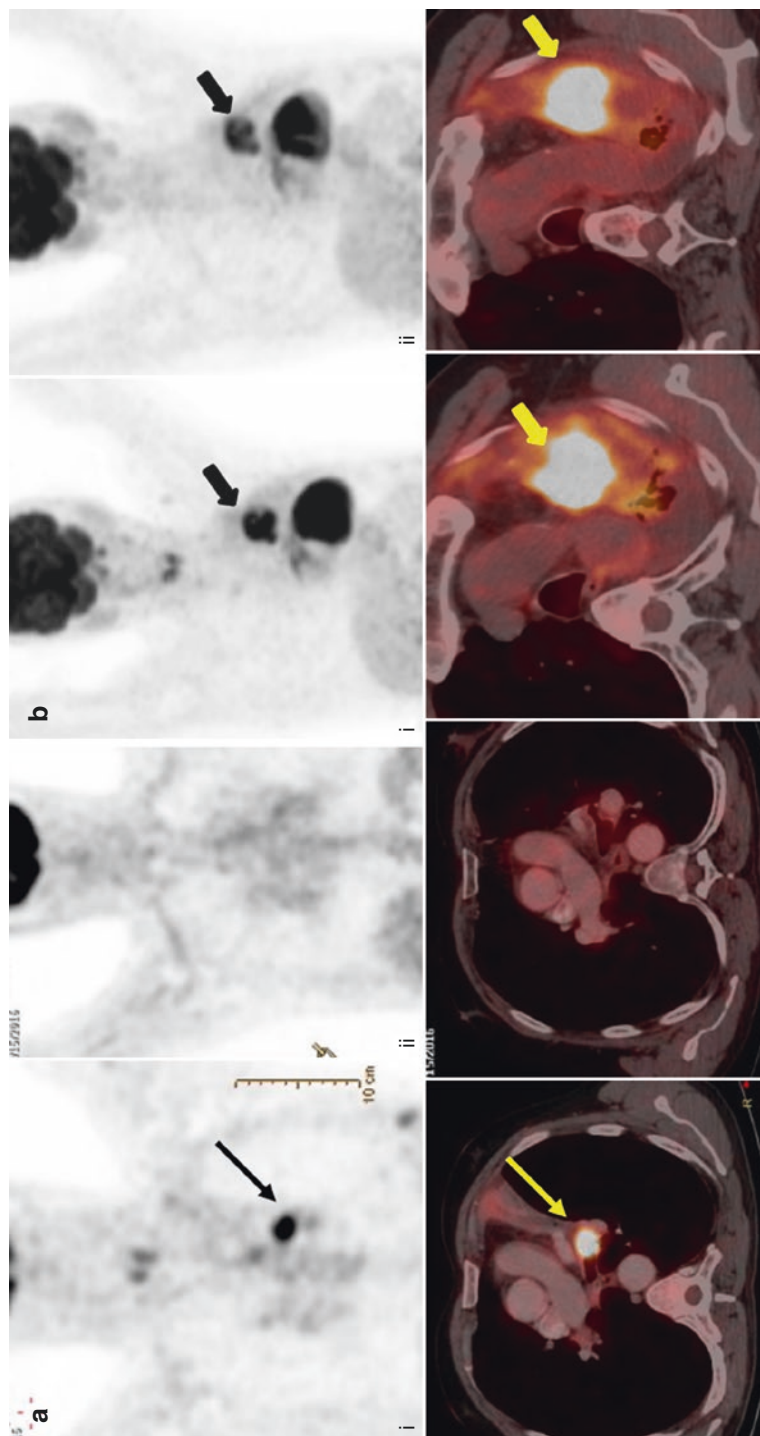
(a) Coronal and axial images of PET/CT of a 66-year-old male showing hypermetabolic left hilar mass (arrow in [i]). Post-chemoradiotherapy there is complete resolution of the mass as seen in [ii]. (b) Coronal and axial images of PET/CT of another patient with adenocarcinoma of the left lung, showing hypermetabolic left hilar mass (block arrow in [i]). Post-chemoradiotherapy there is neither metabolic nor morphologic response (block arrow in [ii])
